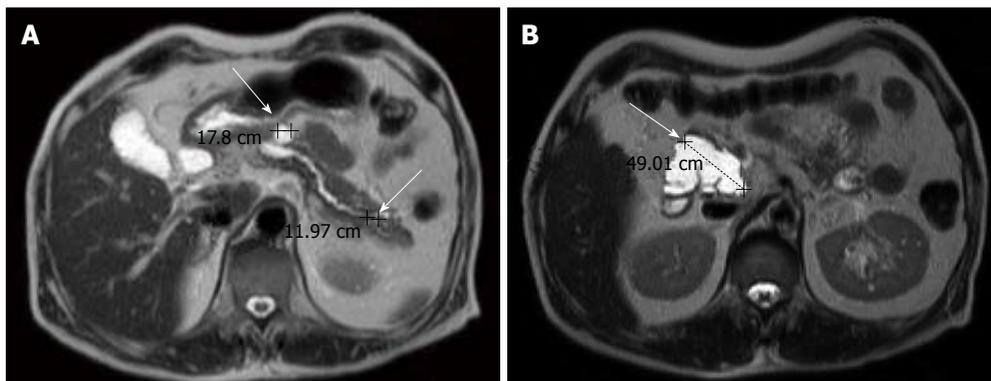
Magnetic resonance imaging showing three cystic lesions in the pancreatic head (4.9 cm), body (1.8 cm) and tail (1.2 cm), with P-duct dilatation. Mild common bile duct and common hepatic duct dilatation without definite tumor was observed in the liver upon MRI.
